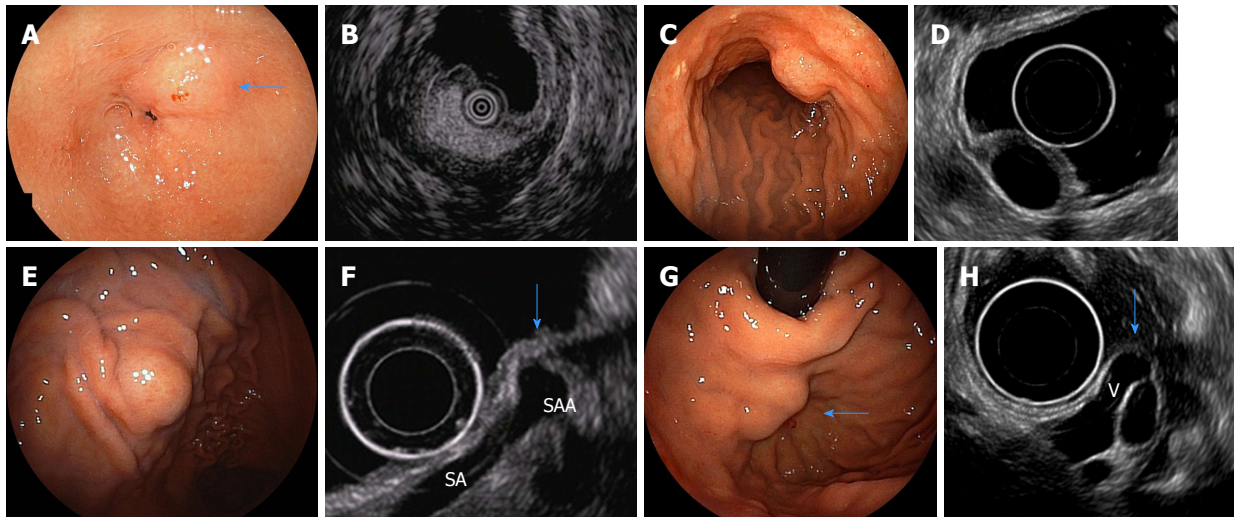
Endoscopic images of subepithelial lesions that can be diagnosed only with endoscopic ultrasound findings and their specific endoscopic ultrasonography images. A: Endoscopic image of a gastric lipoma (arrow); B: Endoscopic ultrasound (EUS) image of A (high-echo mass); C: Endoscopic image of a gastric cyst; D: EUS image of C (anechoic mass); E: Endoscopic image of extra-gastric compression due to splenic artery aneurysm; F: EUS image of E [normal gastric wall is compressed by a splenic artery aneurysm (SAA) (arrow). SA: splenic artery]; G: Endoscopic image of gastric varices (arrow); H: EUS image of G [varices are present in the submucosa from the outside of the wall (V) (arrow)]. Quoted and modified from reference^[38] with permission.
